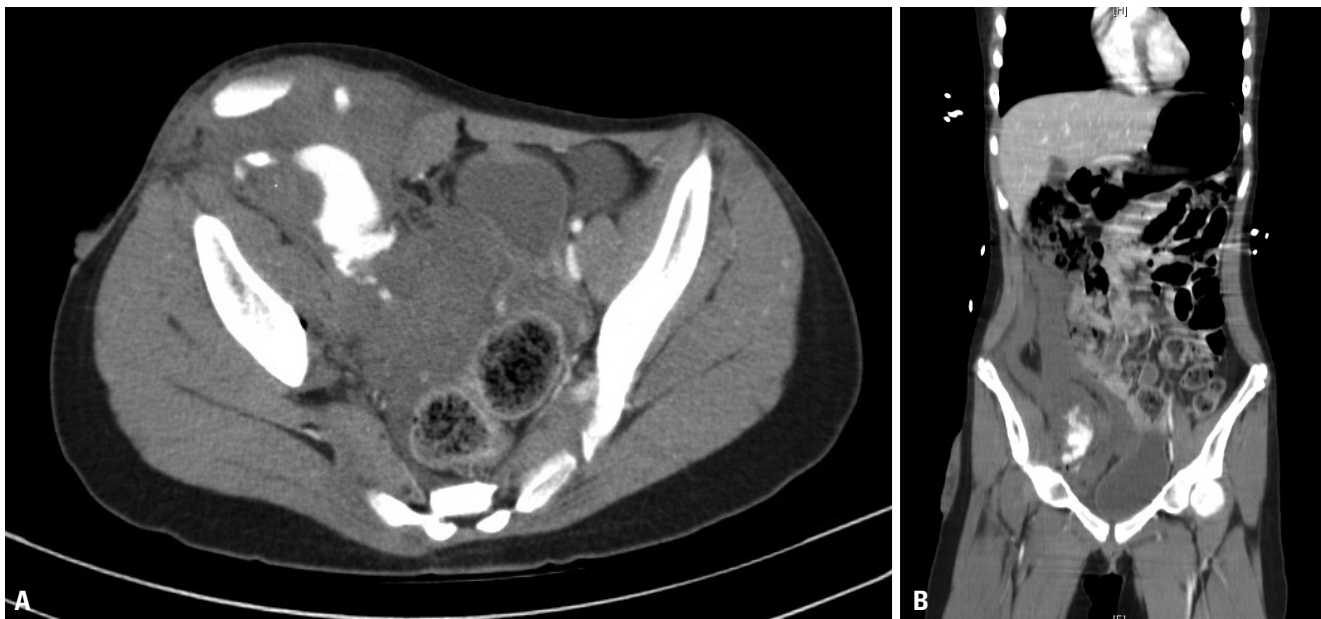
(A) Preoperative abdominopelvic computed tomography showing a large amount of hemorrhagic fluid collected at the right extraperitoneal space and anterior abdominal wall with active bleeding. (B) On coronal view.
